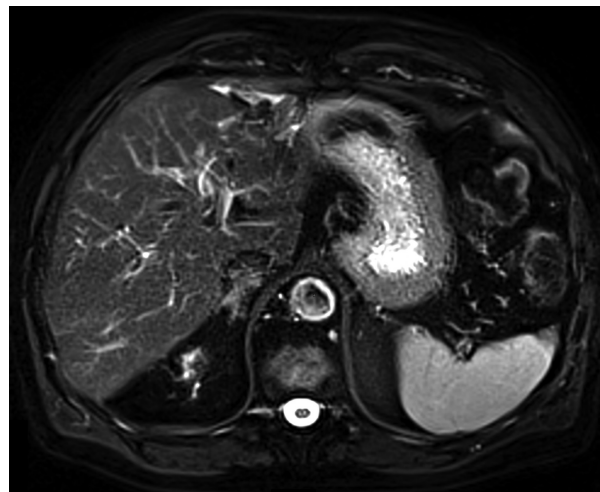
Follow-up magnetic resonance imaging (MRI) 12 months after ablation – no recurrence of the tumor.
